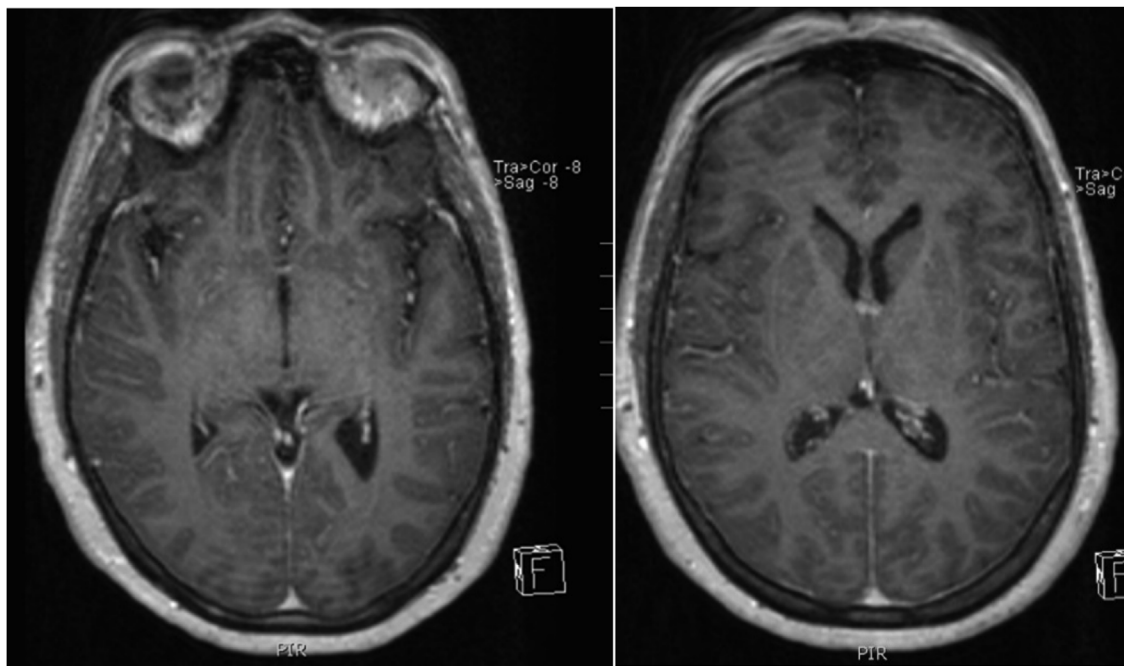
MRI-FLAIR (Fluid-attenuated inversion recovery) study depicting gyro hyper-intensity on the FLAIR study pre-contrast and post-contrast. The post contrast MRI image depicts meningeal enhancement through gyro hyper-intensity on the FLAIR study.
